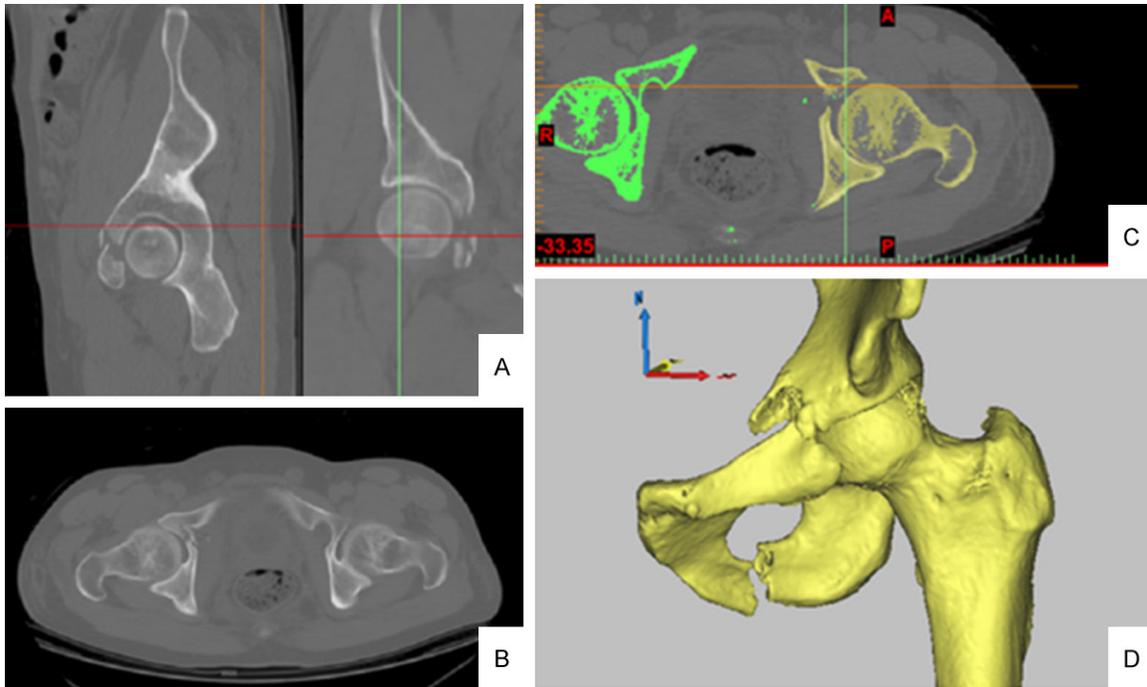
CT DICOM data (A, B) and computer-designed virtual models (C, D) of a 42 year-old male patient revealed a displaced fracture on the right acetabulum involving the inferior pubic ramus.
